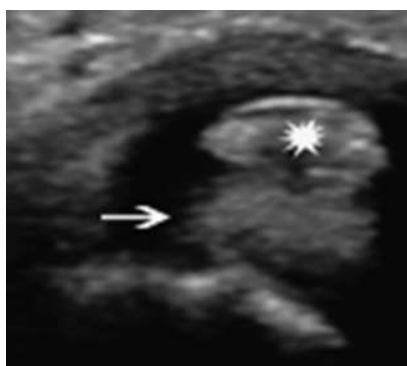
Postoperative short axis ultrasound image of the wrist shows the fat graft (arrow) adjacent to the ECU tendon (star).
